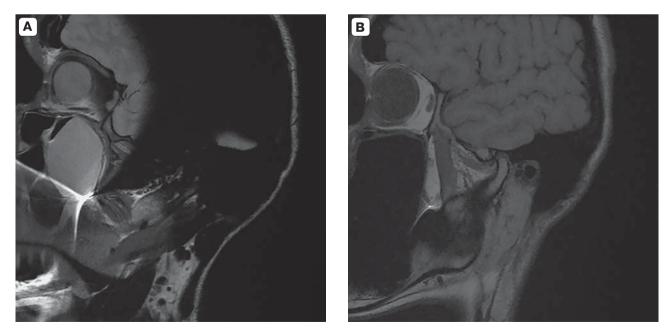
MRI of the TMJ without considering metal structures in the ROI, sagittal plane. A – PD GRE, open mouth position; B – T1 GRE, closed-mouth position.
